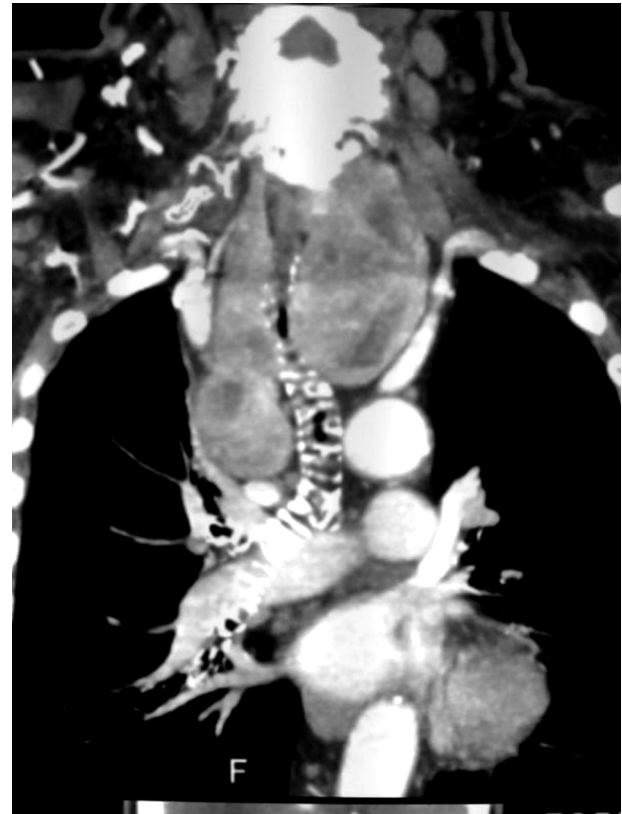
A multidetector computed tomography scan with multiplanar reformatting and volume-rendering reconstruction of the neck and chest shows an extension of the thyroid mass into the upper mediastinum.
